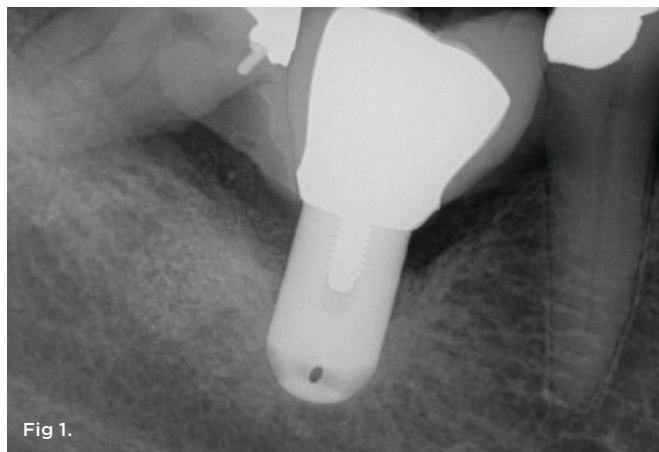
An implant was placed at site No. 30. Immediately after the effect of the local anesthesia subsided the patient complained of paresthesia (no pain) of the mandibular right lip and chin. A periapical radiograph taken at the time of implant placement demonstrated no apparent implant penetration into the inferior alveolar canal. Fig 2. The implant restoration was completed 10 years ago and the patient has been able to accommodate the altered nerve sensation. Recently, the patient presented at one of the authors' offices and a CBCT scan was ordered. It demonstrated that the implant at site No. 30 is closer to the inferior alveolar canal than previously envisioned and may be causing compression on the nerve.
